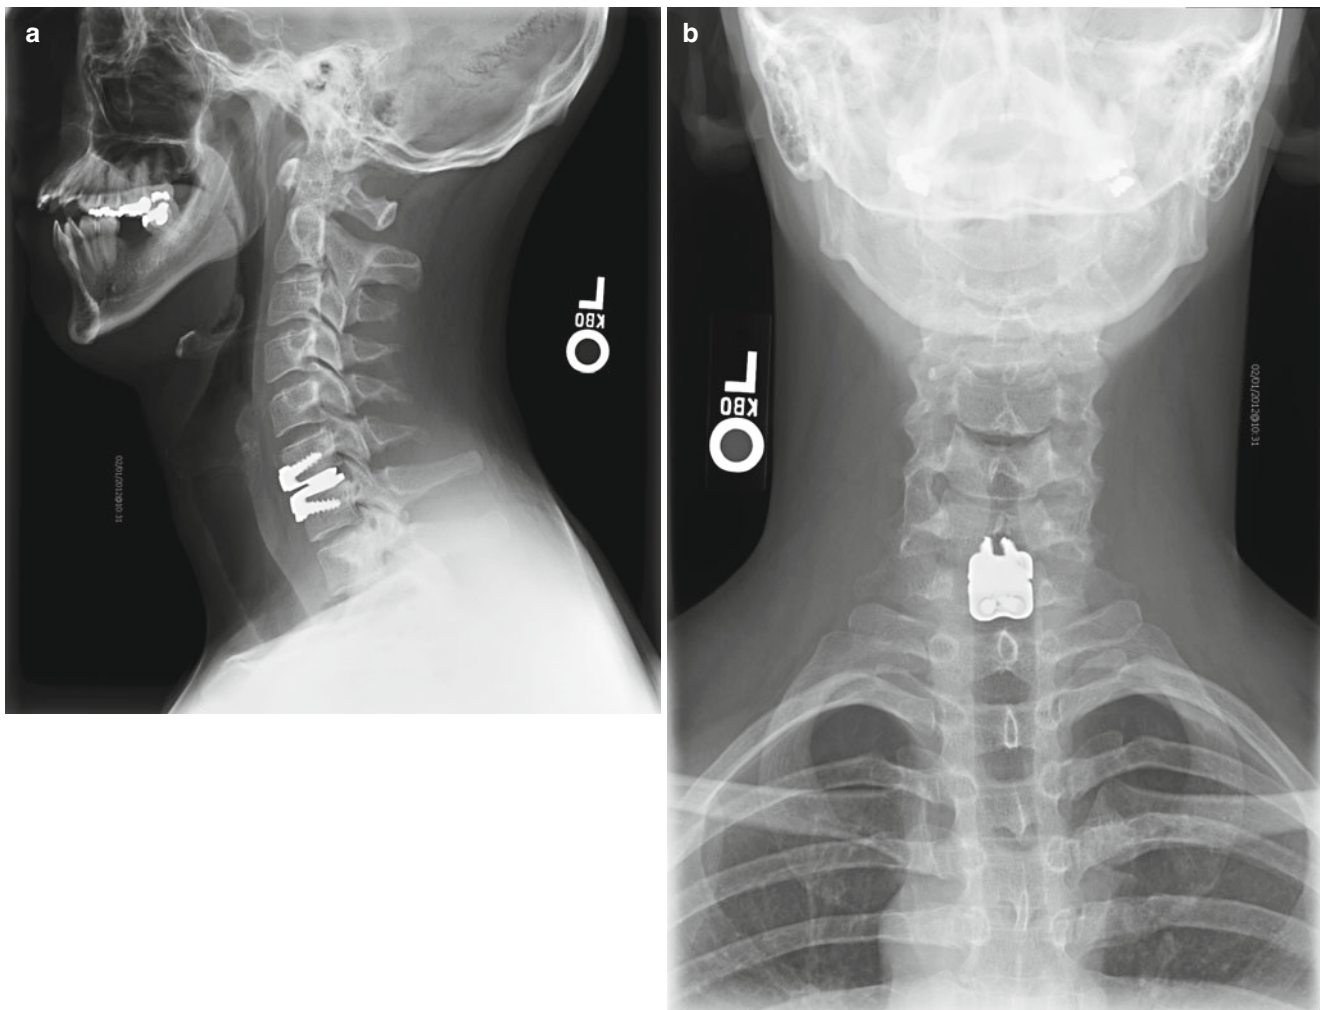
(a, b) Radiographs of patient with single-level Prestige ST cervical disc device
